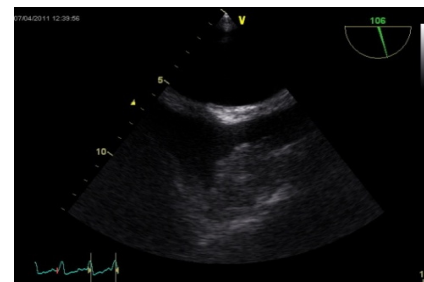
Transesophageal echocardiogram.
